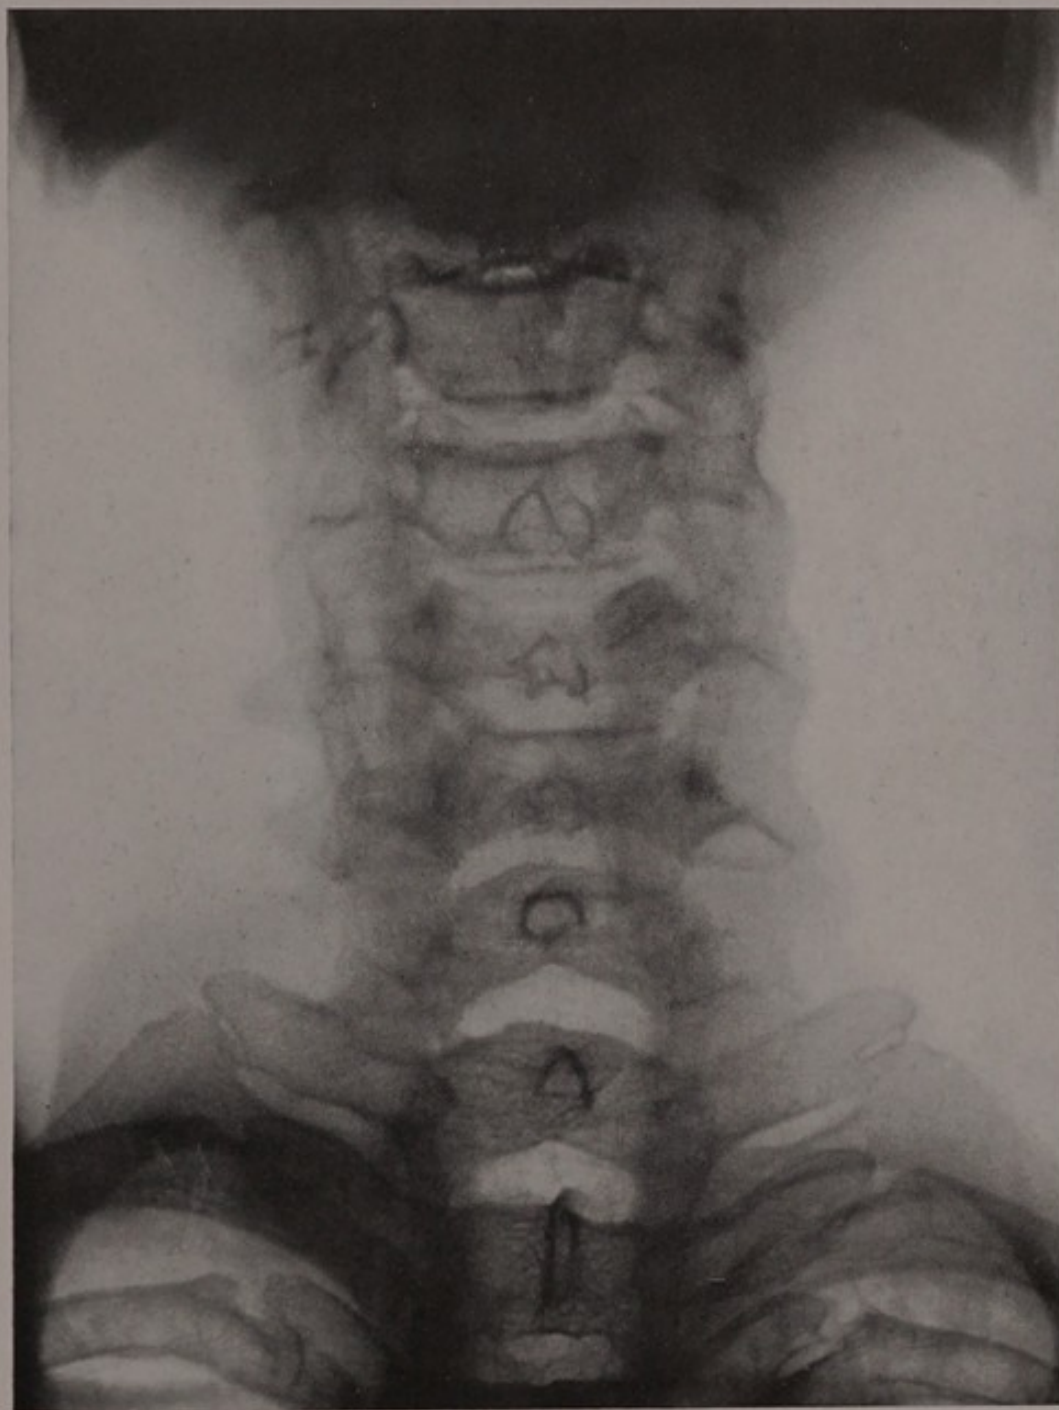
X-ray of normal cervical vertebræ, antero-posterior view.
